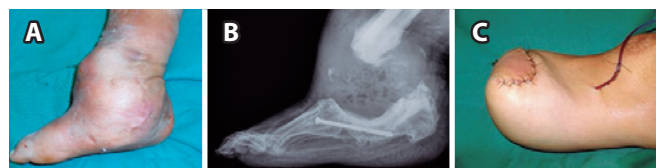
Medial view of a severely deformed and bulging right foot and ankle (4A). A lateral radiographic image of the foot and ankle (4B) shows extensive bone resorption after an unsuccessful surgical reconstruction attempt. The patient underwent transtibial amputation (4C).
